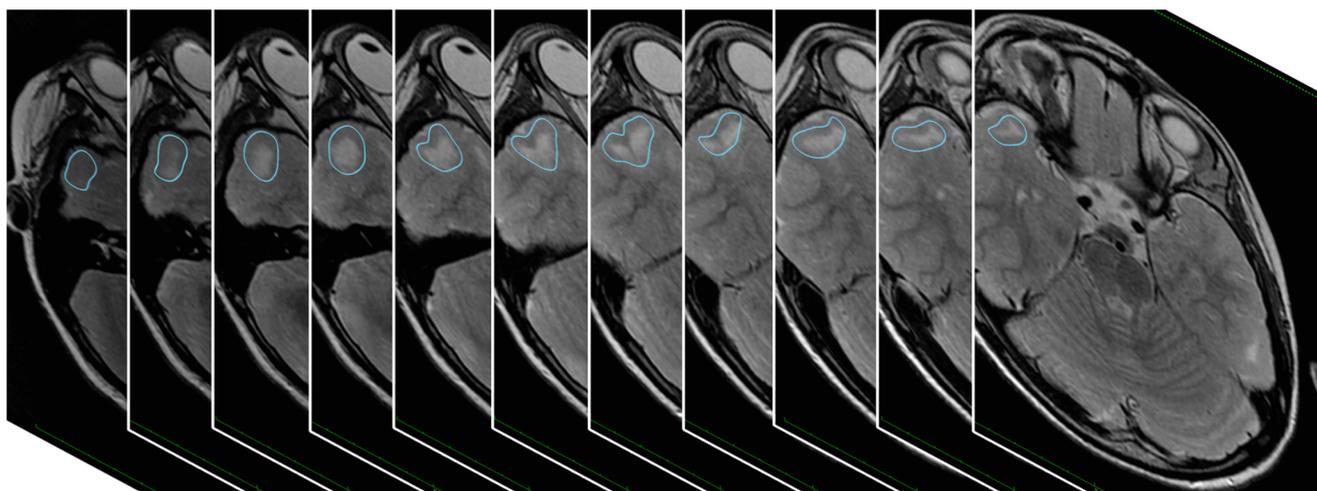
Overlay of pre-operative T-2 weighted MRI images in OSiriX demonstrating how cortical tuber volumes were calculated using the ROI draw and ROI volume functions
